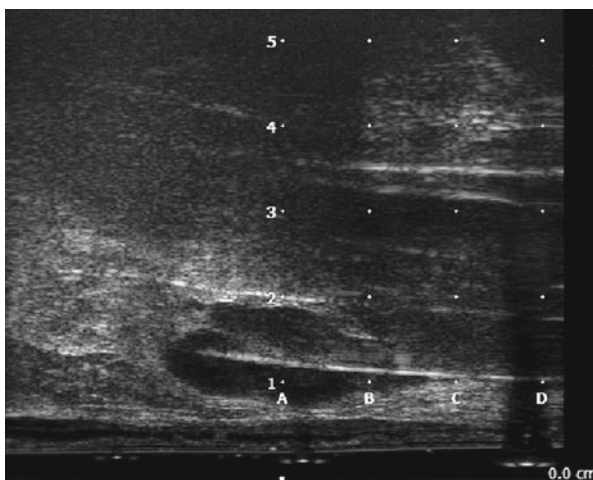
Sagittal ultrasound image to show catheters placed within seminal vesicles
